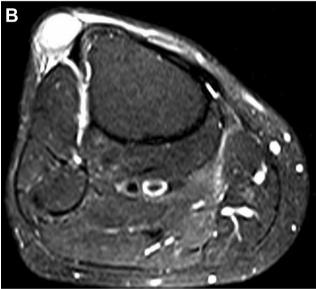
Radiographic appearance. Magnetic resonance imaging demonstrated a well-circumscribed, soft tissue lesion without connection to the underlying tibia (see upper left corner of images). (A) T1 weighted image, demonstrating isointensity. (B) T2 weighted image, demonstrating hyperintensity.
